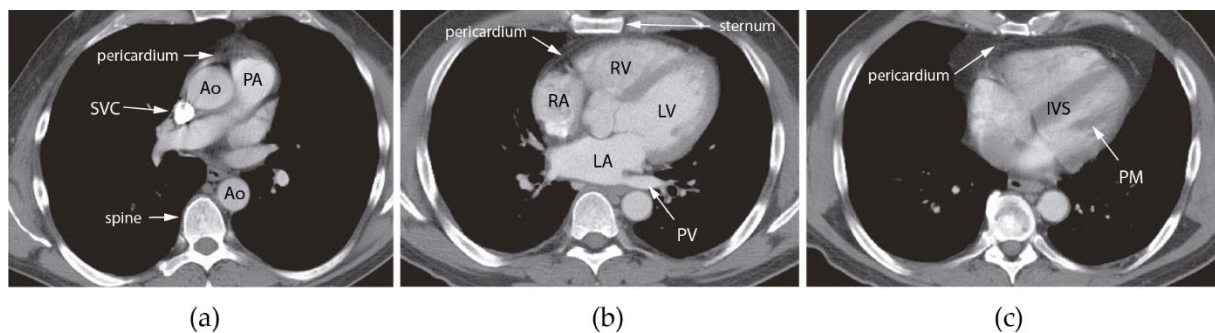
Heart anatomy in chest contrast-enhanced computed tomography images from superior (a), valvular (b) and inferior (c) levels. Adapted from Kanza et al. [38]
